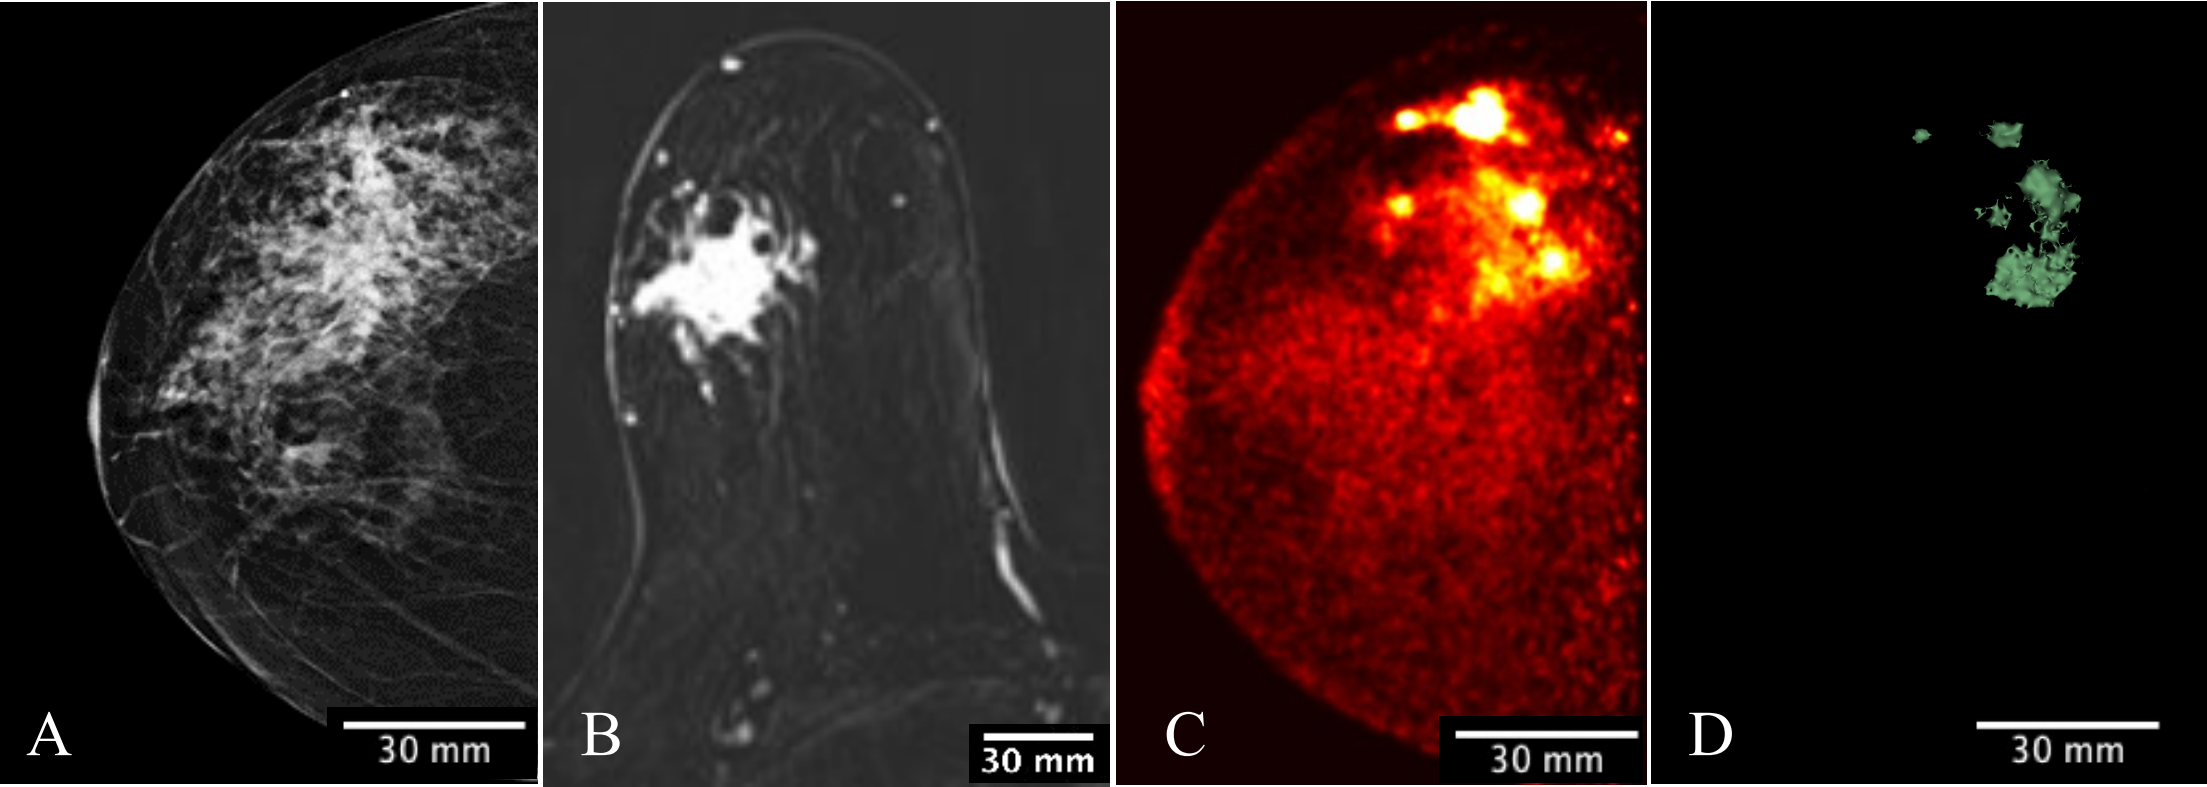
A 61-year-old female with right-breast multifocal invasive and in situ ductal carcinoma. Images of the same breasts in (A) FFDM in the CC plane showing extensive distortion, (B) a selected slice of MRI in the axial plane showing irregular shape-enhancing lesion 2 min post gadolinium-chelate-based contrast administration, (C) Radialis PET in the CC plane showing multiple distinct regions of contrast uptake 3 h after injection of 178 MBq  $^{18}\text{F}$ -FDG, (D) 3-D volume generated from Radialis PET in the CC plane based upon tissue metabolism threshold across all image slices.
